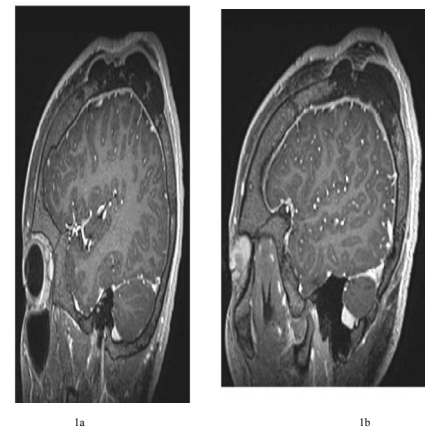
MRI showing subgaleal hematomas over the (a) frontal and (b) parietal bones.
